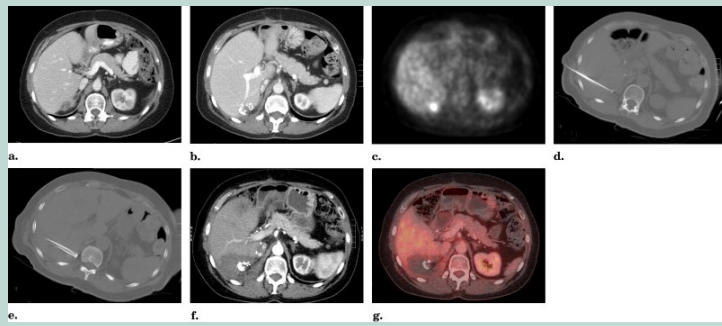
(a) Seventy-year-old woman who presented with a solitary liver metastasis after colon resection for colonrectal carcinoma. (b,c) The patient had this lesion surgically resected, but there was evidence of local progression on follow-up PET/CT. (d,e) This area was treated with multiple overlapping radiofrequency ablations with a cluster probe. (f,g) The 18-month follow-up PET/CT continues to show large hypoattenuating ablation zone without fluorodeoxyglucose avidity, consistent with local treatment response. Source: Journal of Vascular and Interventional Radiology 2010; 21:S214-S222 (DOI:10.1016/j.jvir.2010.01.046)
